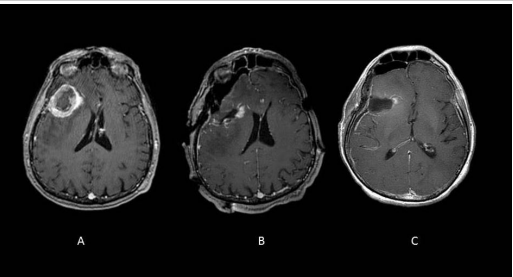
T1 contrasted MRI of right temporal glioma resection with (A) preoperative image. Intraoperative image (B) shows residual tumor, this was resected. Postoperative image (C) shows gross total resection.
